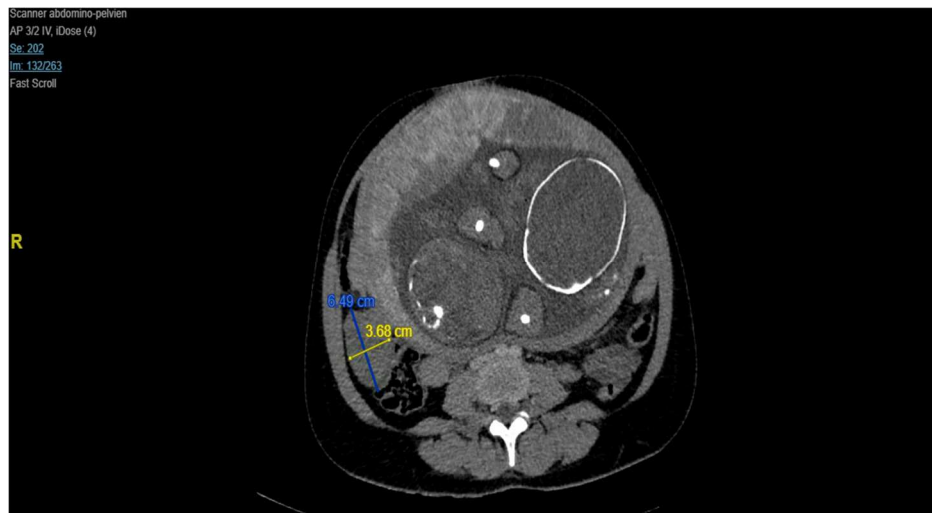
Ovarian mass on CT scan axial image
